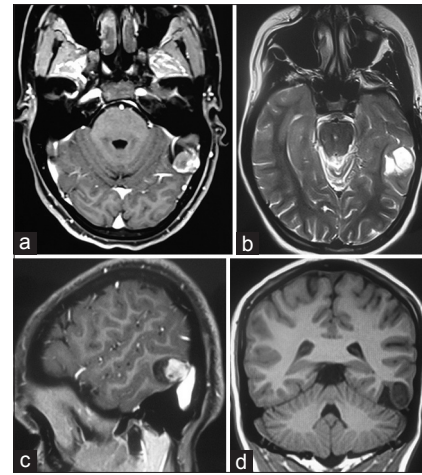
(a) Axial T1-weighted with gadolinium enhancement. (b) Axial T2-weighted. (c) Sagittal T1-weighted with gadolinium enhancement. (d) Coronal T1-weighted with FLAIR. Preoperative images showing a lesion of size about 2 cm × 2 cm involving the posterior part of the right inferior temporal cortex
